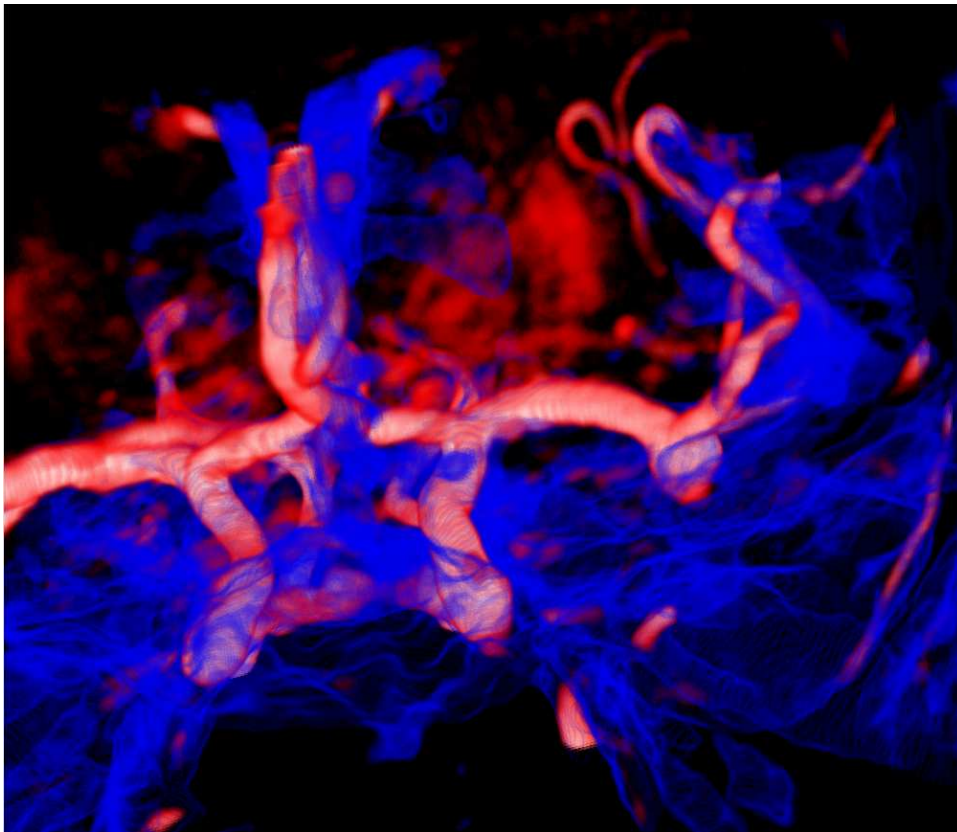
Volume renderings of MRI T1 (*blue*) and MRA (*red*)
